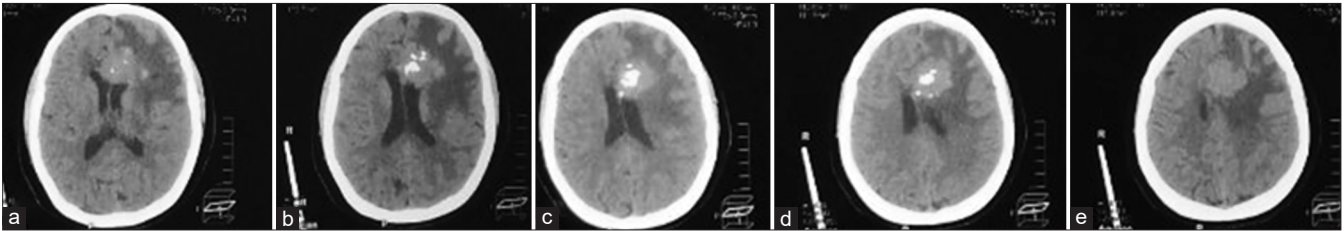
(a-e) Axial brain computed tomography (CT) scans without contrast images, which demonstrate a left pericallosal isodense lesion with areas of hyperdensities. The lesion is ill-defined, round-shaped, and measures approximately 3 × 3 cm. It is causing a mass effect on the left frontal horn and minimal midline shift. Diffuse left frontotemporal vasogenic edema is noted.
